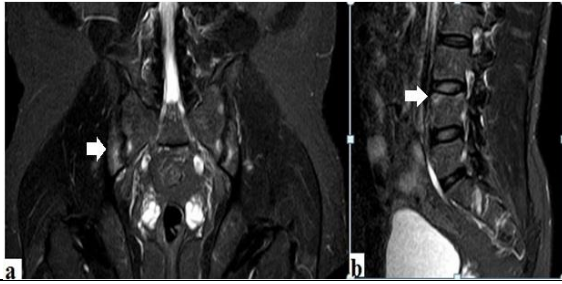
Ankylosing spondylitis, (a) MRI SI joint Coronal STIR sequence showing symmetrical subchondral marrow edema. (b) MRI LS spine Sagittal T2W image showing Romanus lesion at superior endplate of L4 vertebra
